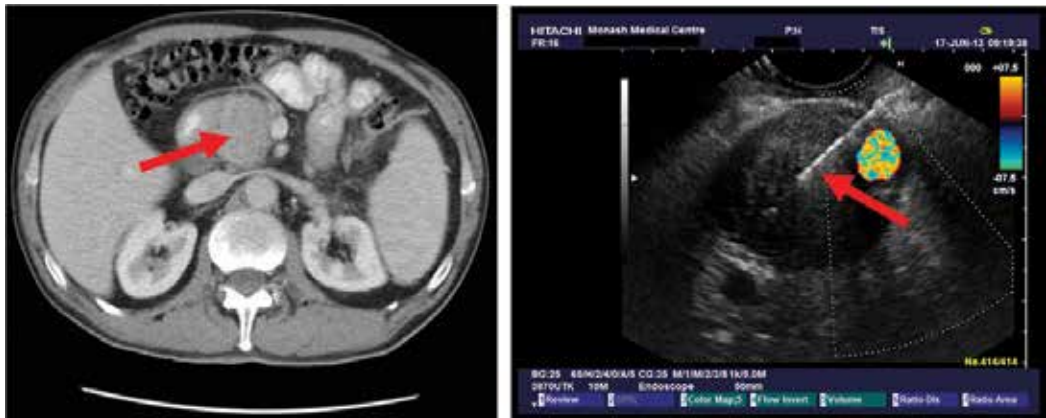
CT and corresponding EUS image of a pancreatic mass that proved to be autoimmune pancreatitis.
